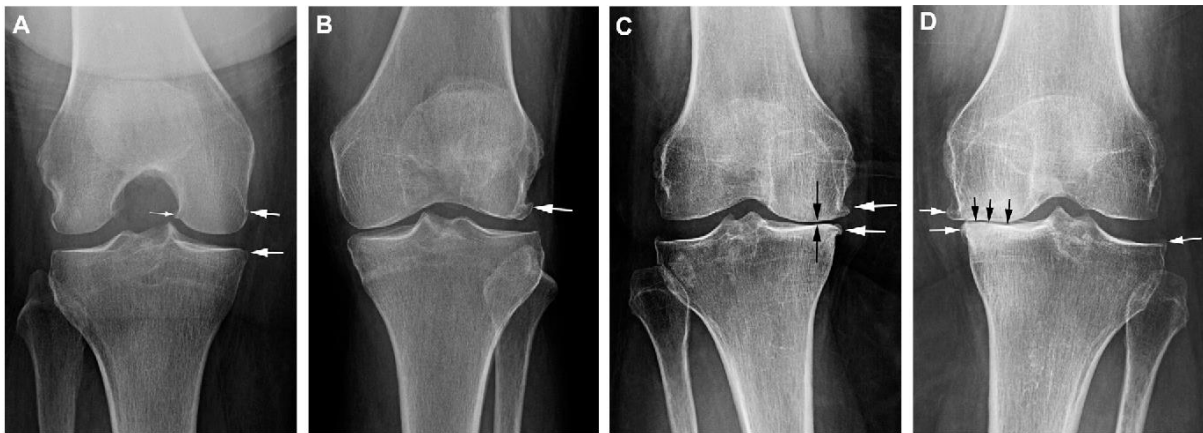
Radiographic images of Kellgren- Lawrence grades 1-4. (A) grade 1, minimal formation of osteophytes at arrows. (B) grade 2, evident osteophyte. (C) grade 3, joint space narrowing, in addition to osteophytes. Image (D), grade 4, bone to bone contact and osteophytes [24].
